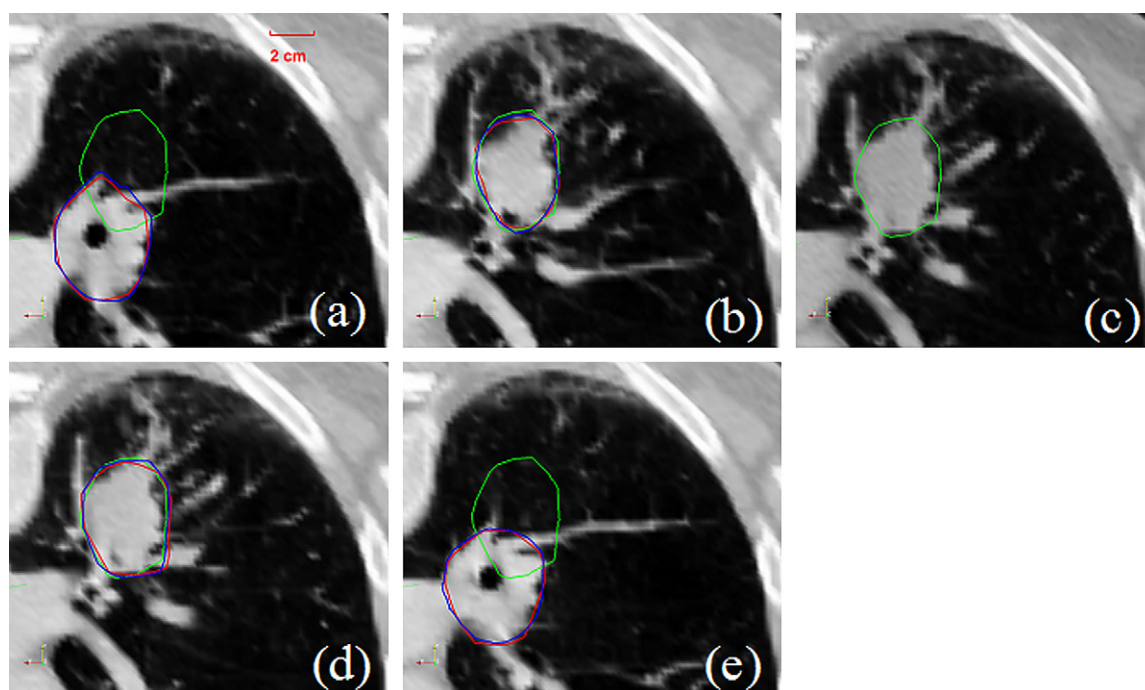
Axial view of computed tomographic images with gross tumor volume contours for the fourth thoracic patient. (a), (b), (c), (d), and (e) correspond to phases 1, 4, 6 (template phase), 8, and 10, respectively. The green curves are the manually outlined template contour from phase 6, and the red curves represent the contours after warping. The manual contours (in blue) by a physician on individual phases were also displayed.
